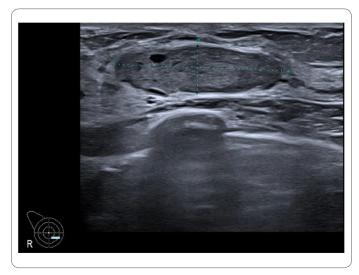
Ultrasound of the right breast with a mass measuring 3.6 cm.
